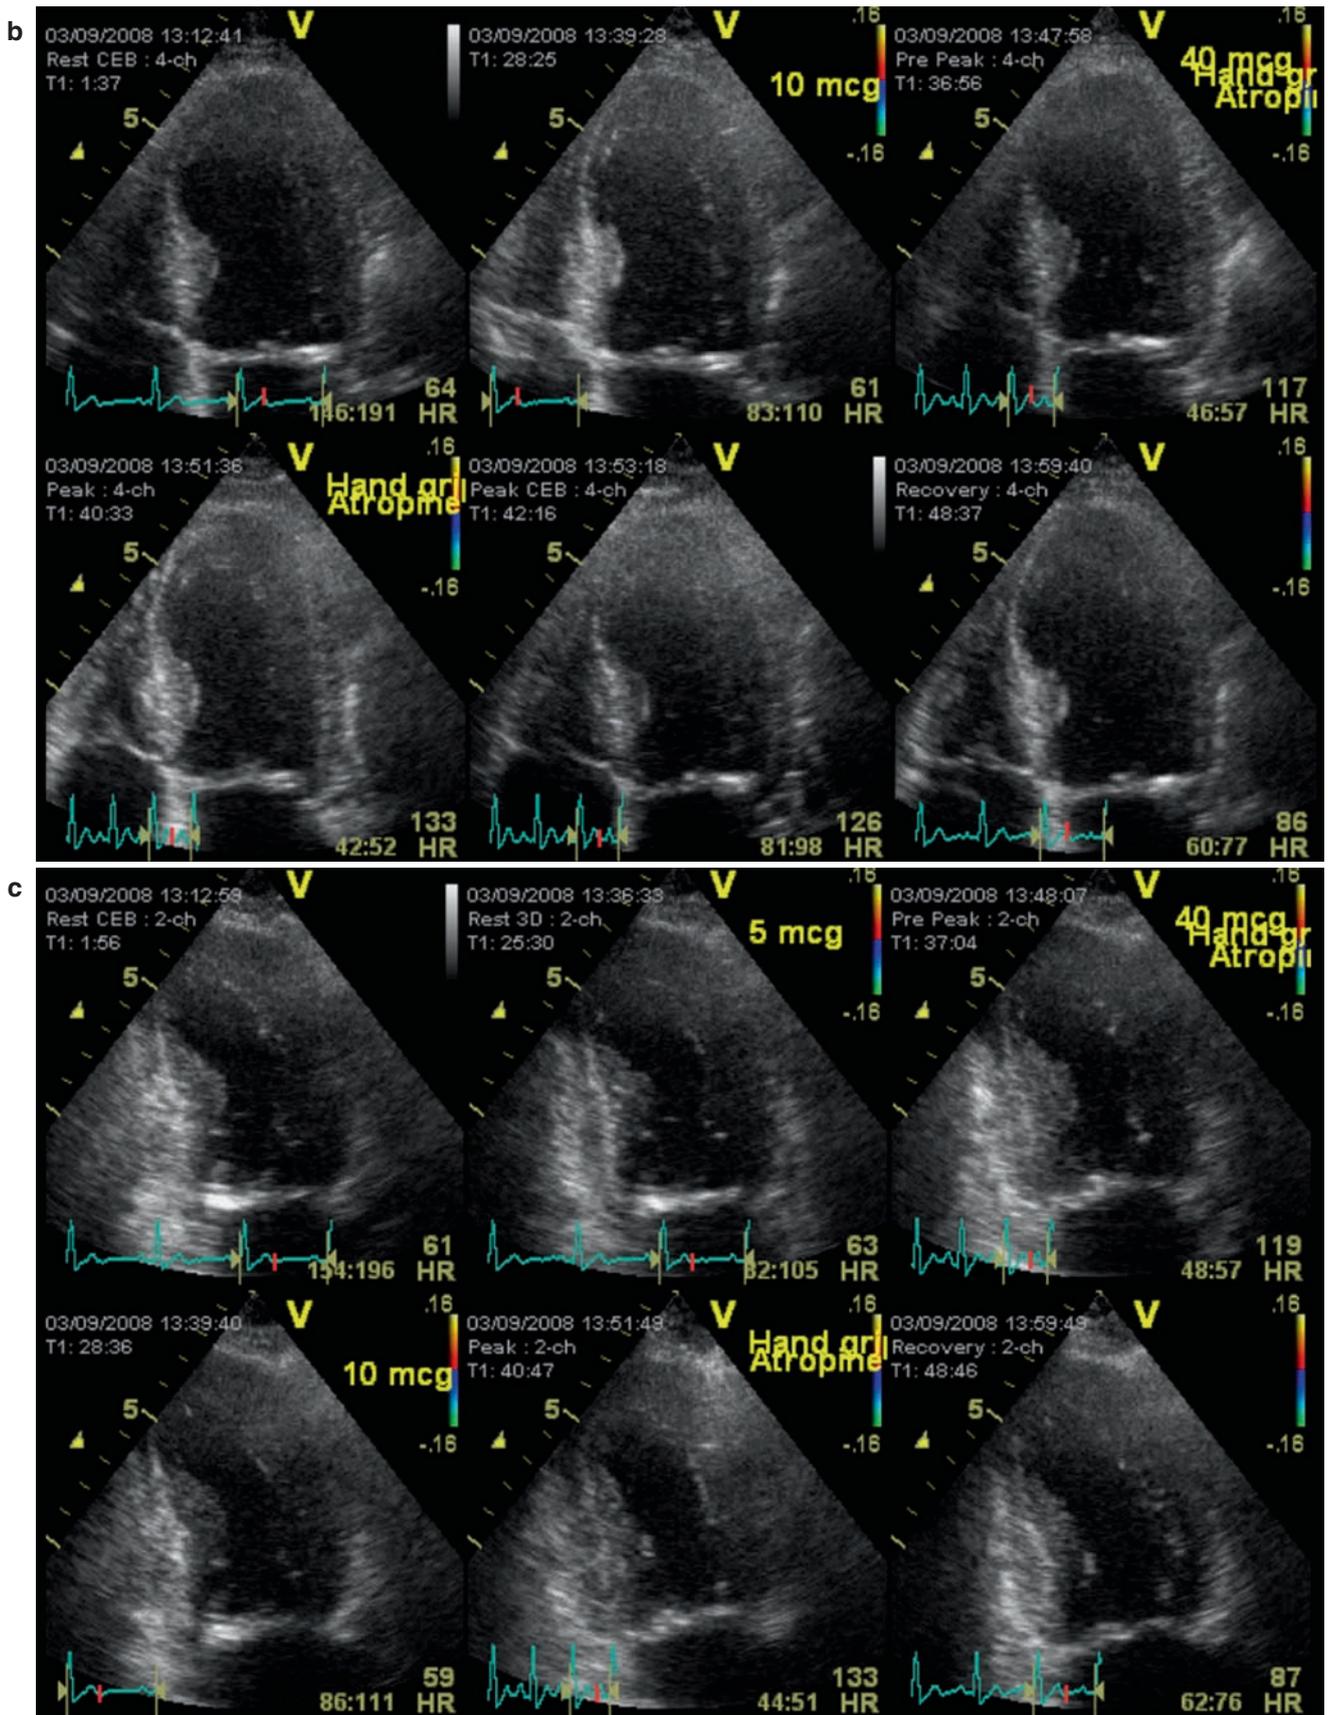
(b) End-systolic images at rest, low dose, peak dose, and recovery in the apical 4-chamber view. The apical and mid-septal akinetic area does not change at low dose, and therefore suggests a non-viable area. The apical lateral wall improves at peak stress, indicating non-transmural infarction. (c) End-systolic images at rest, low
